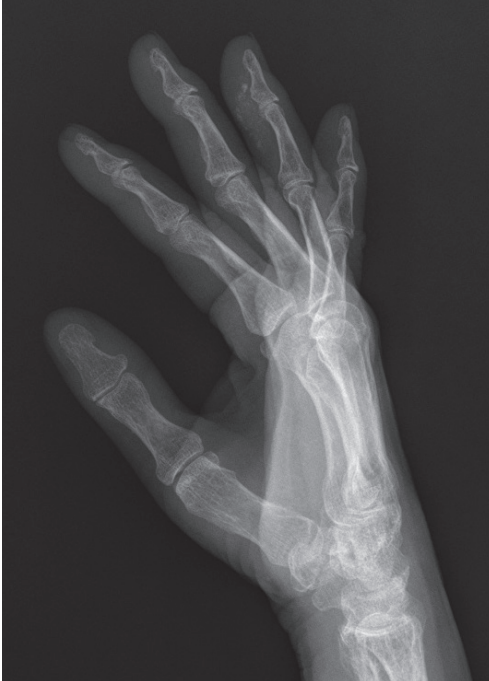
Follow-up radiographic findings after two months showed the spontaneous resolution of the calcification.
